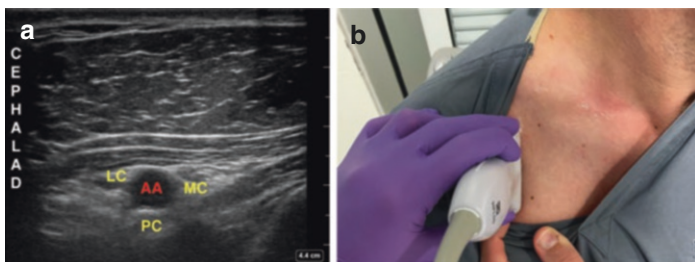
(a) Ultrasound image of infraclavicular approach to brachial plexus nerve blocks. *AA* axillary artery, *LC* lateral cord, *MC* medial cord, *PC* posterior cord. (b) Ultrasound probe placement to obtain infraclavicular view
